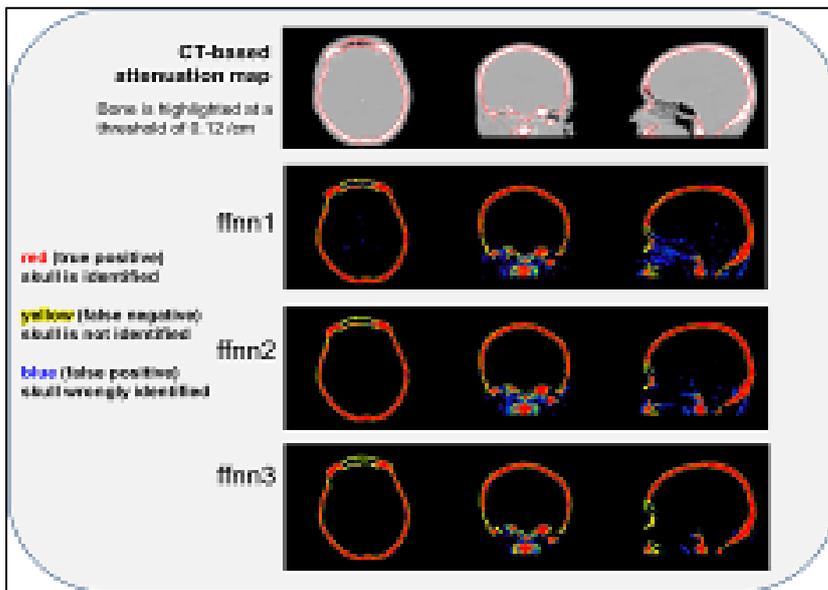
Exemplarily the bone tissue images of one subject from the three different segmentation methods together with the corresponding CT-based attenuation map are shown.
